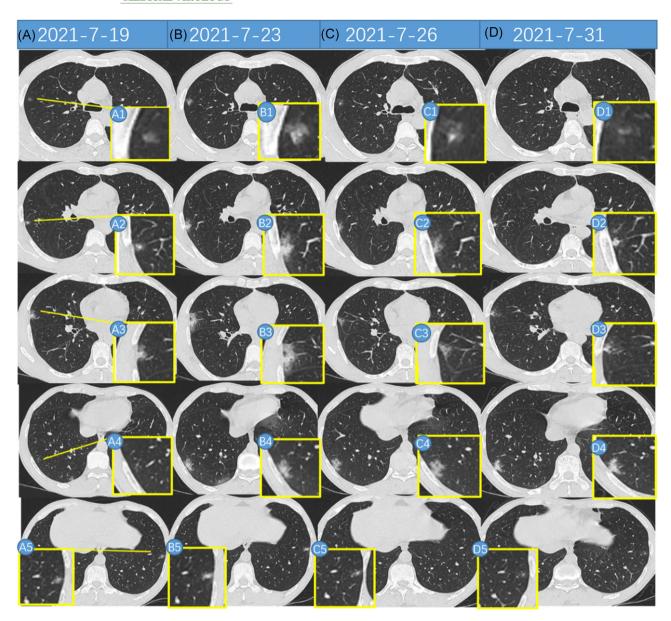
Multiple follow-up computed tomography (CT) images of a typical case of the SARS-CoV-2 Delta Variant of Concern. (A) The first vertical images are the initial CT of 2021-7-19, multiple lesions in bilateral pulmonary, all of which are small nodules. The local magnification is shown in A1-A5. The lesions appear as ground-glass nodules or nodules with halo signs. (B) The second vertical images are the follow-up CT of 2021-7-23, which corresponds to the same level of panel A. Compared with the previous CT, the density and size of nodules increase in B1-B5, and some of the nodules appear to fuse into patches in B1-B4. (C) The third vertical images are the follow-up CT of 2021-7-26. C1-C5 correspond to the same level as the previous CT. Through the local enlargement, the lesion becomes smaller, indicating that the lesion has improved. (D) The fourth vertical images are the follow-up CT of 2021-7-31. Lesions were further reduced by contrasting the same level with the previous images in D1-D5, and the edge was straight in D4, indicating that the lesion has entered the repair period
